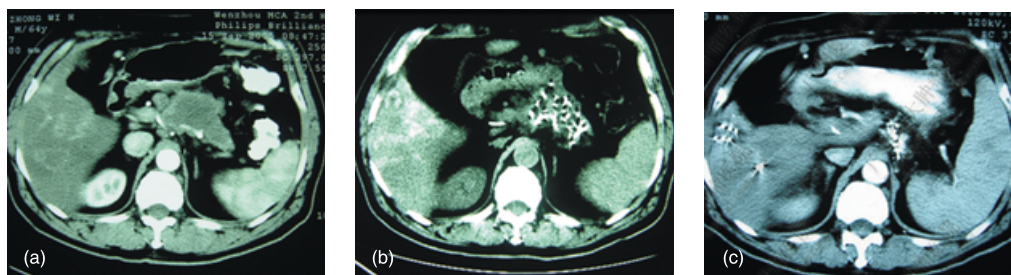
Computed tomography scan of patient 2 (a) before treatment, a mass was seen in pancreatic body and tail, (b) 1 month after treatment and (c) 6 months after treatment.
